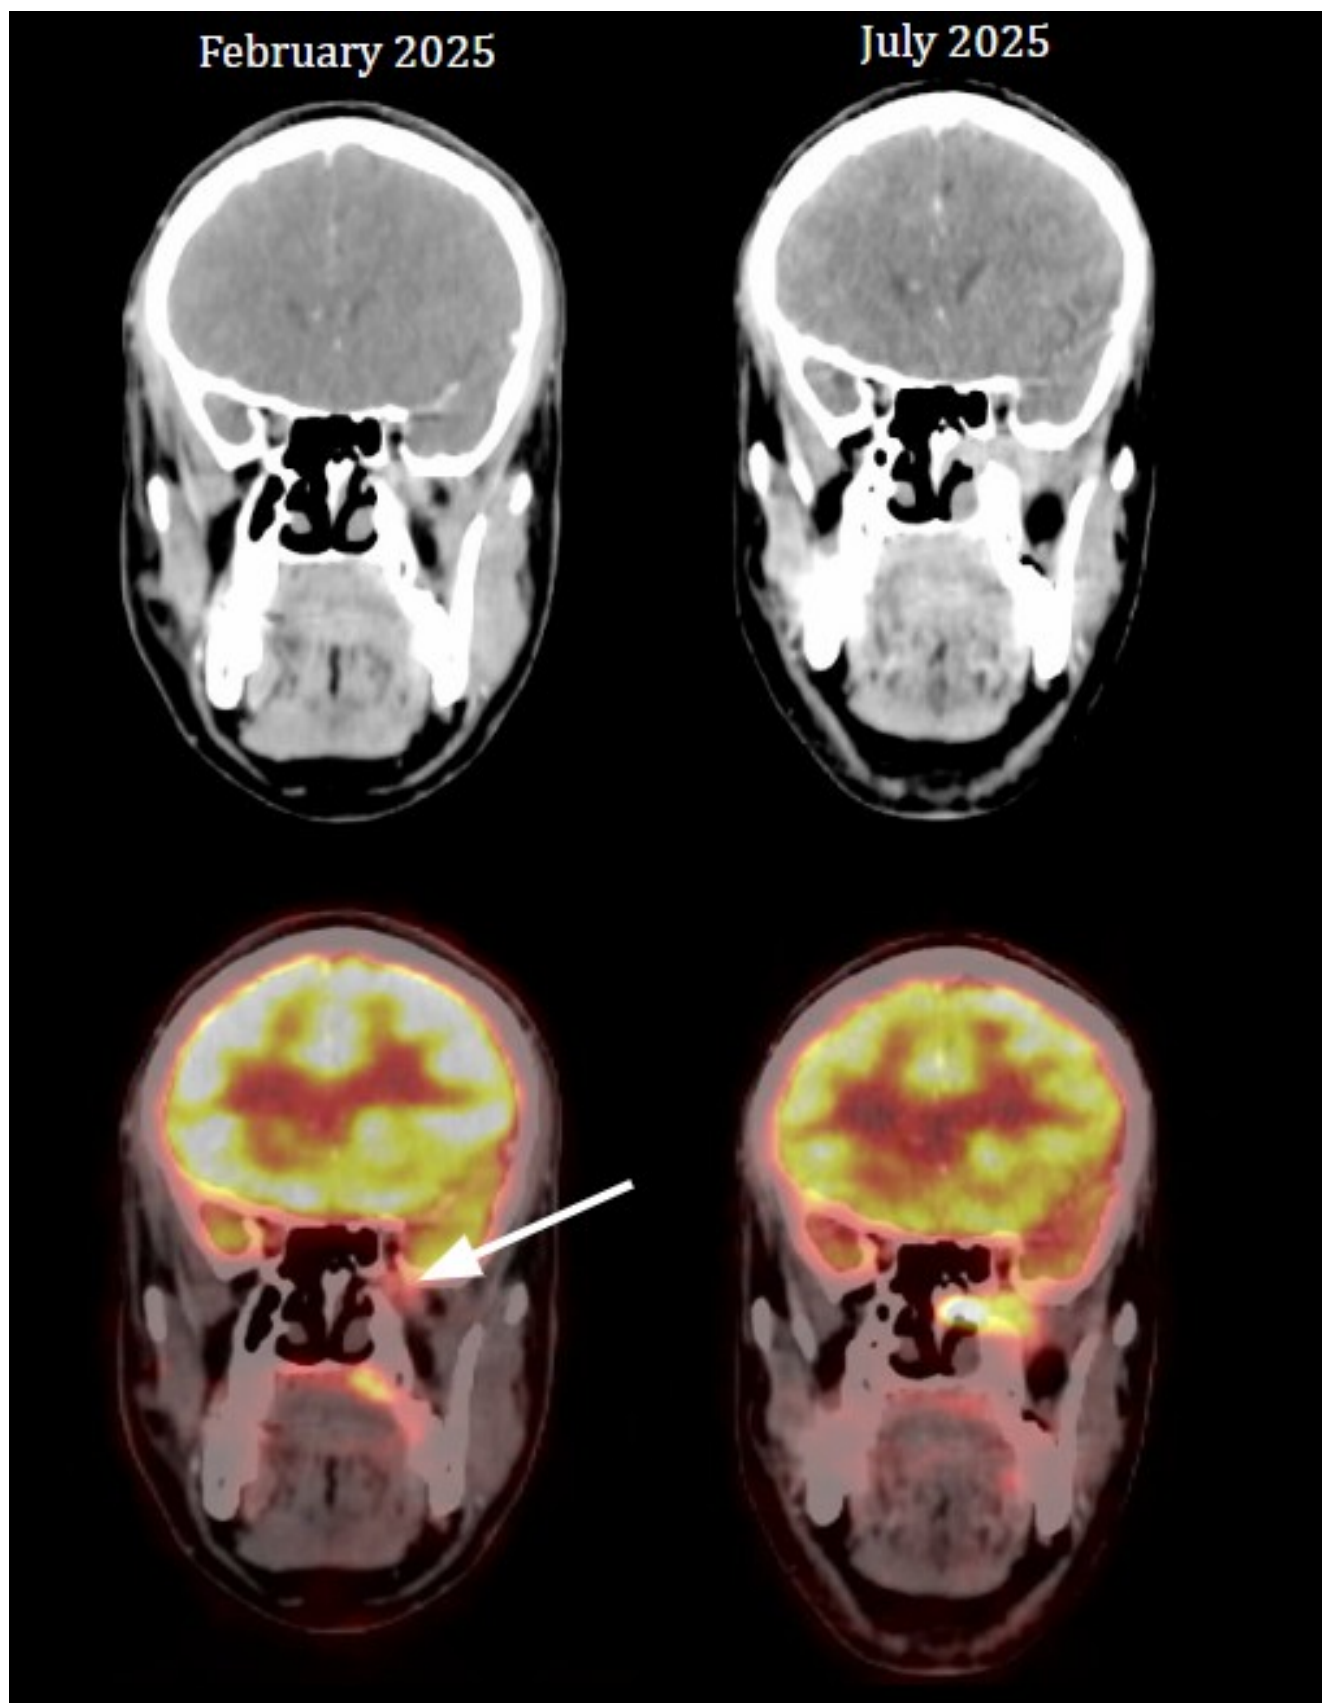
Coronal CT and fused PET/CT images. The right panel (July 2025) clearly demonstrates a hypermetabolic lesion in the left nasal cavity involving the middle turbinate and its posterior horizontal attachment, abutting the sphenoidal crest and vomer medially. Laterally, the lesion extends into the left pterygopalatine fossa. The left panel (February 2025) shows a subtle, FDG-avid thickening in the same site (arrow) that was initially overlooked.
